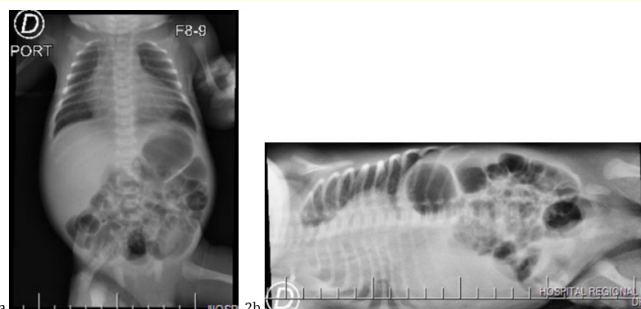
X-ray of anteroposterior abdomen (Figure 2a) and lateral abdomen with horizontal lateral ulnar ray (Figure 2b). Presence of probe in distal third of the esophagus, normal intestinal luminogram, distal air present, no signs of pneumoperitoneum, silhouette of solid organs visualized within normal limits, no significant alterations in bone structures are observed.
